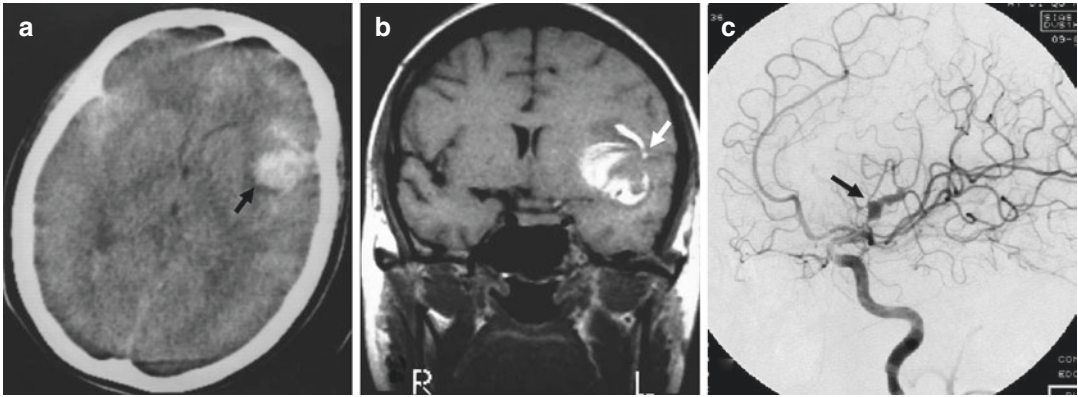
A 36-year-old female presented with a giant serpentine aneurysm. (a) CT scanning showing a giant hypertensive mass in the left Sylvian fissure (arrow). (b) Coronal view of the T1-weighted MR imaging showing a
